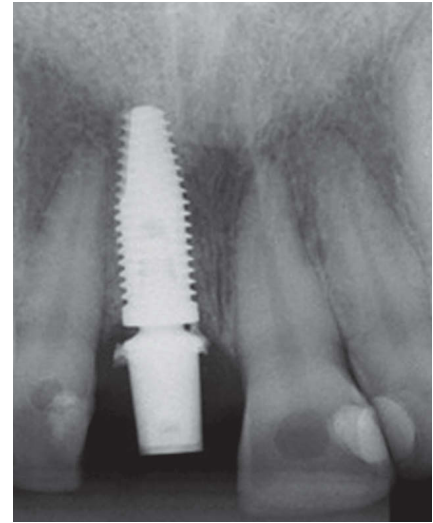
Control radiograph after three weeks. Well-positioned 1-2 millimeter infraosseous implant.
